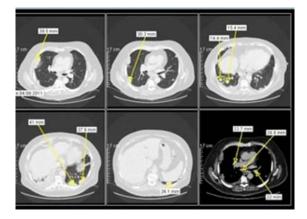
CT scan showed pulmonary metastases
